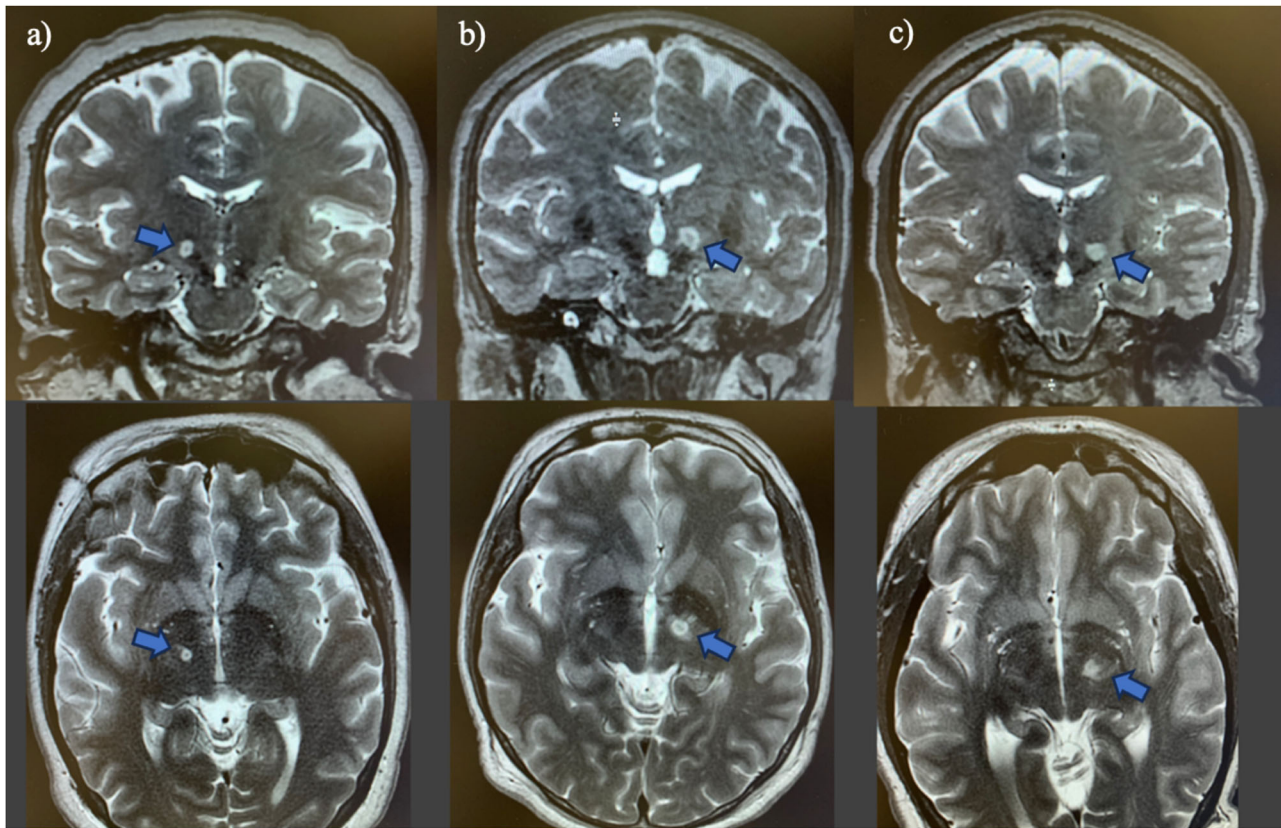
Immediate post-treatment unilateral subthalamotomies. Examples of coronal and axial T2-weighted MRI views obtained immediately after the procedure from STN10 (a), STN5 (b) and STN12 (c) participants (with different degrees of cytotoxic oedema). The site of the lesion is recognizable by a heterogeneous central
